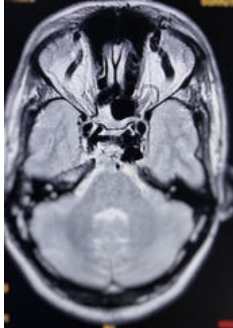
c. MRI BRAIN T2 sequence showing flow voids of B/L ICA communicating with cavernous sinus with prominent B/L superior ophthalmic veins suggestive of Type A CCF.
